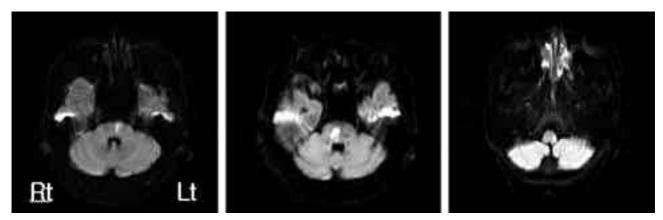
Diffusion weighted MR images of patients who showed contralateral VEMP abnormalities according to the lesion(2 pons, 1 medulla lesion).
